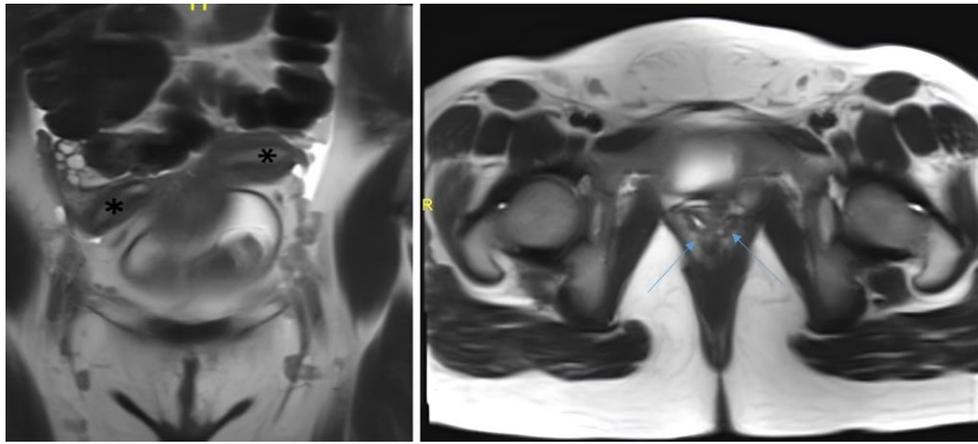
Pelvic MRI T2 sequence demonstrates duplication of uterus (*), cervix, & vagina (arrow) (reprinted with permission of the patient)
